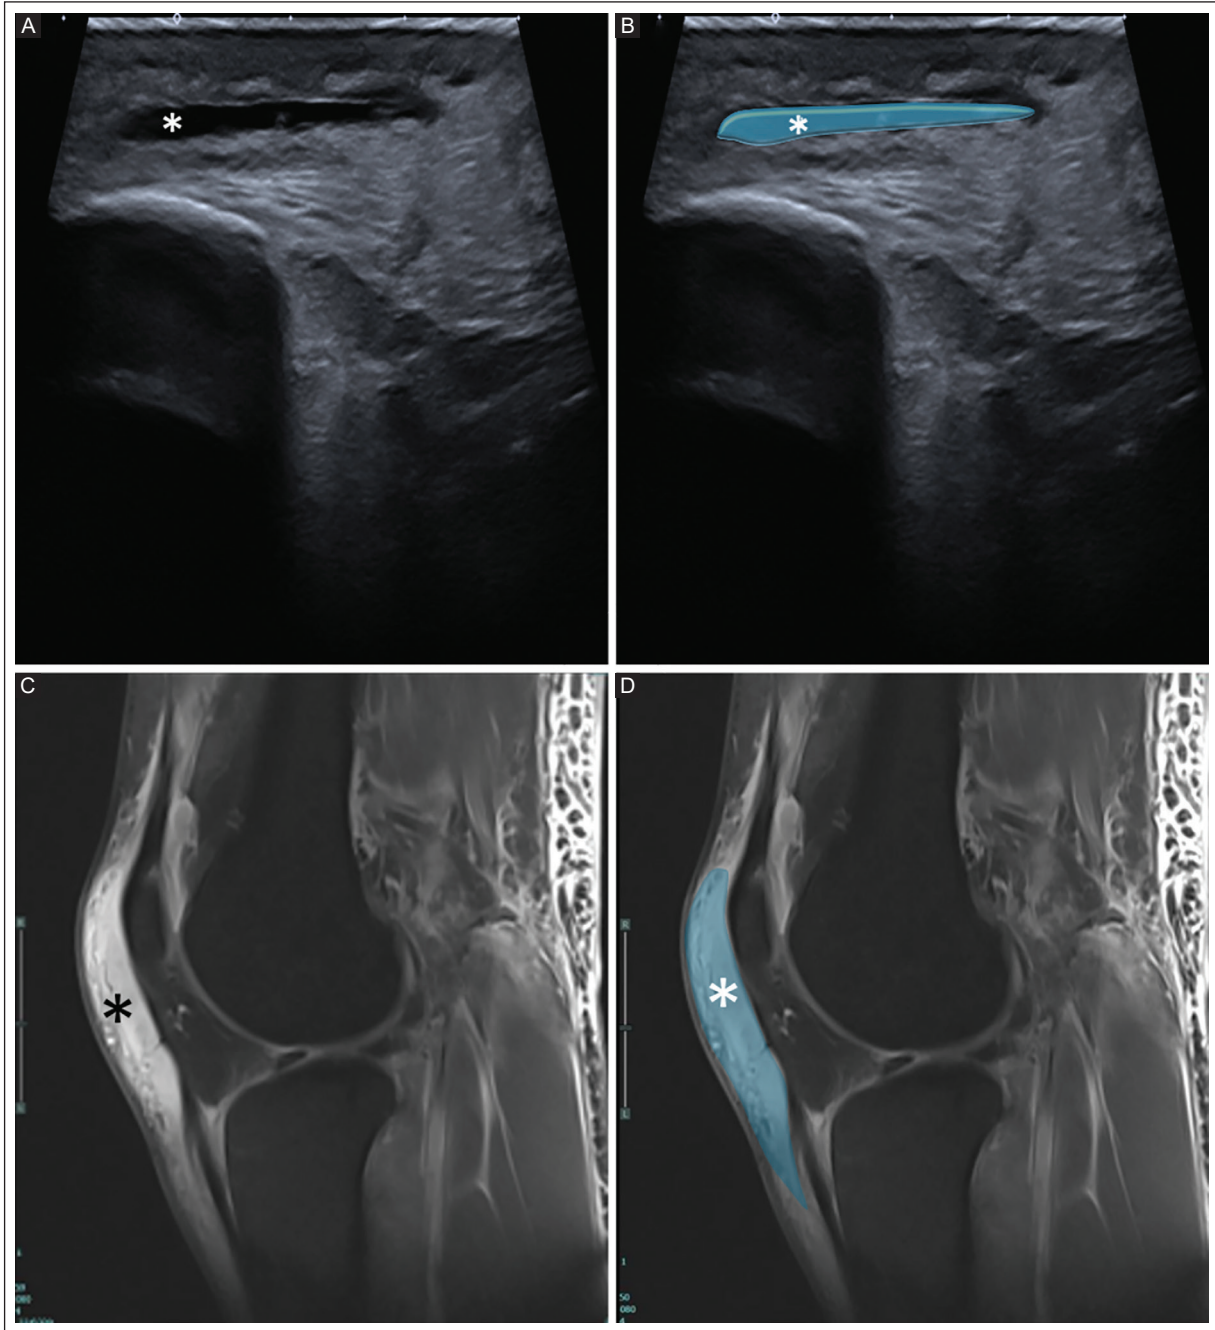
A-B: sagittal knee US in a 30-year-old man shows superficial prepatellar bursitis, characterized by well-defined anechoic fluid collection in the prepatellar bursa (asterisks), highlighted in blue. C-D: sagittal proton density-weighted knee MRI with fat suppression shows a marked hyperintense fluid signal distending the superficial prepatellar bursa (asterisks), highlighted in blue, consistent with superficial prepatellar bursitis (“housemaid’s knee”).
